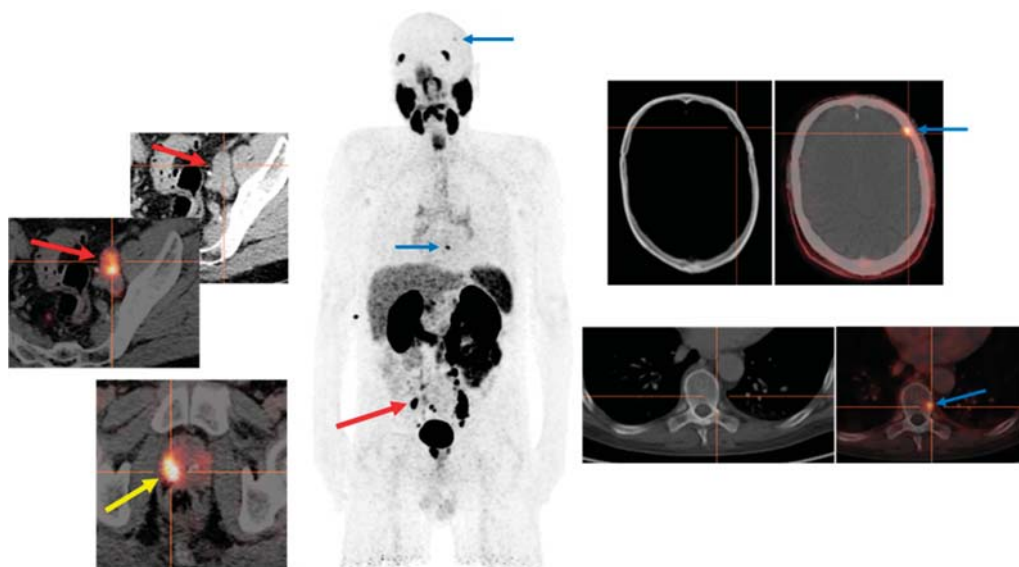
PSMA PET examination for primary staging of a high-risk prostate cancer. PSMA PET-CT Images for primary staging of a 56 year old man, newly diagnosed with PCa: Gleason score (5 + 5) and a PSA value of 45.96 ng/mL showing two PSMA-avid bone lesions frontoparietal in the left side of the skull and the ninth thoracic vertebra (blue arrows) in addition to the primary tumor in the right lobe of the prostate (yellow arrow) and bilateral iliac lymph node metastases (red arrows). Both these bone lesions were not visible on CT examination separately performed for the patient.
